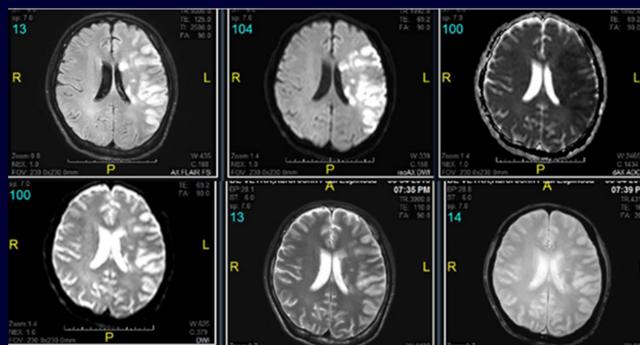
MRI/MRA showed previous infarcts with associated long segment occlusion of the insular and opercular branches of the left middle cerebral artery with paucity of the cortical branches
